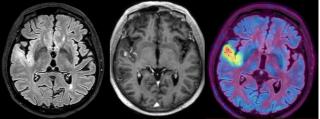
MRI Flair, MRI T1 with Gadolinium, PET-MR.
